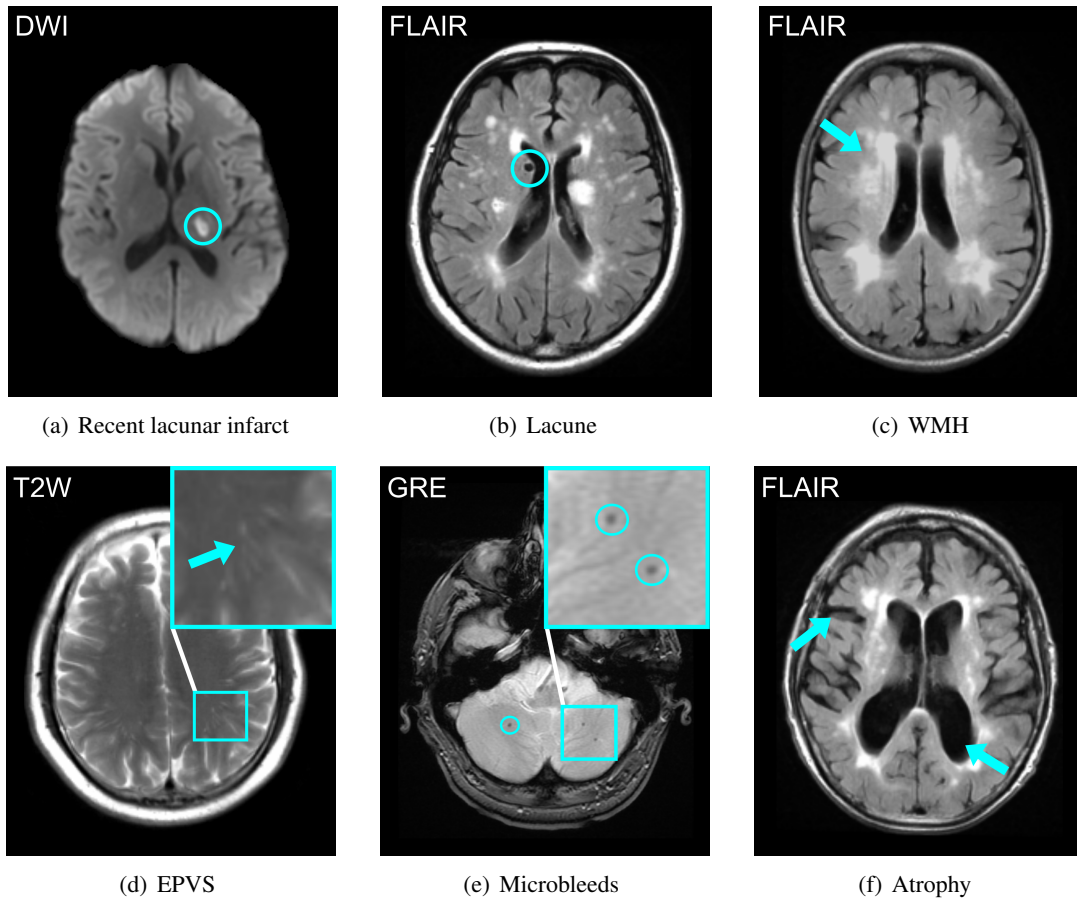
Main MRI findings of cerebral SVD. Example images showing SVD imaging features on different MRI sequences. (a) The circle highlights a recent small subcortical infarct, (b) the circle highlights a fluid filled lacune, (c) the arrow points to a region with WMH characteristics (WMH are diffuse lesions which include all regions of similar hyperintense signal), (d) the square contains several linear EPVS, which are also visible on the contralateral side, (e) the circles highlight cerebral microbleeds, (f) the arrows point to the enlarged ventricles and enlarged sulci respectively, representing cerebral atrophy.
